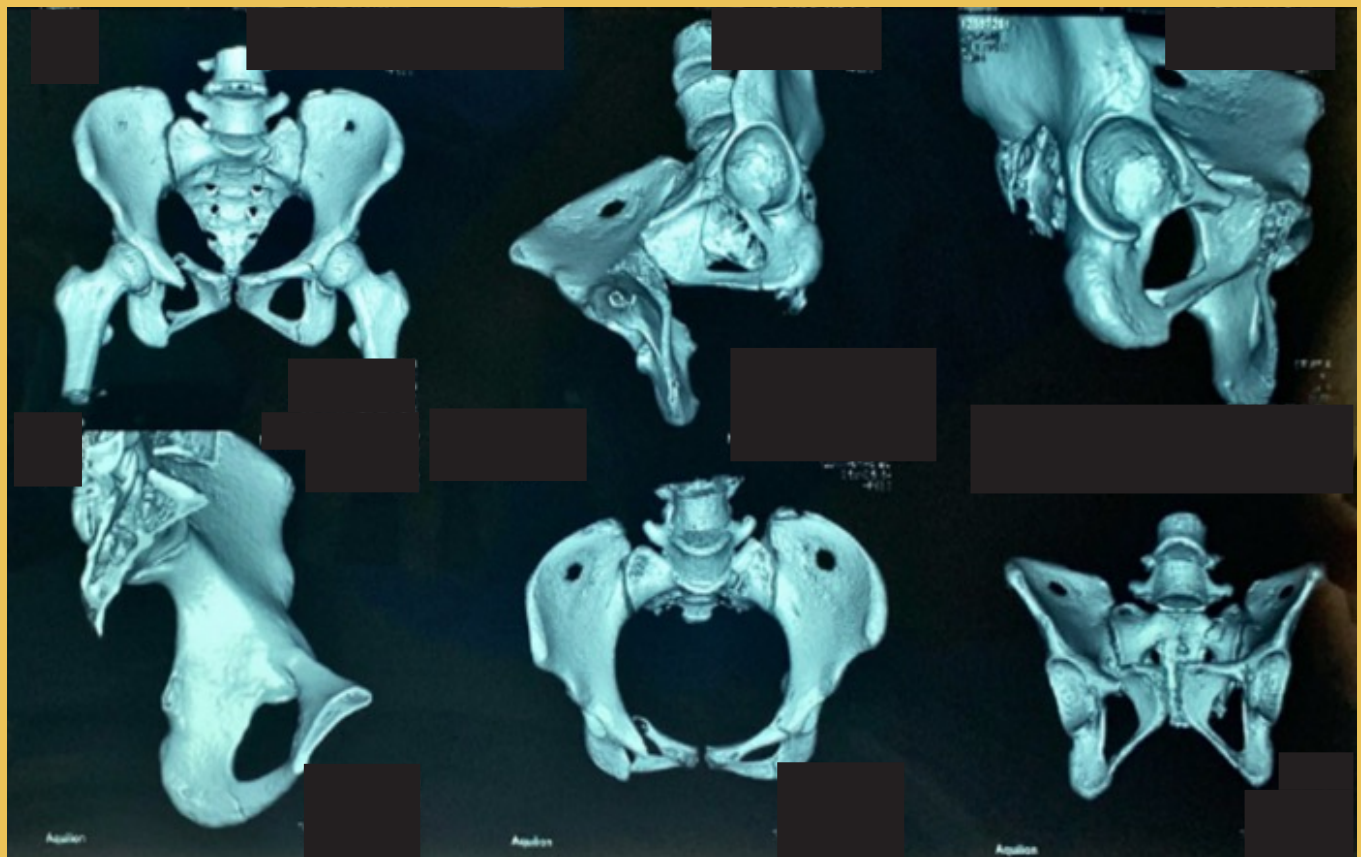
Preoperative three-dimensional reconstructions CT scan.
